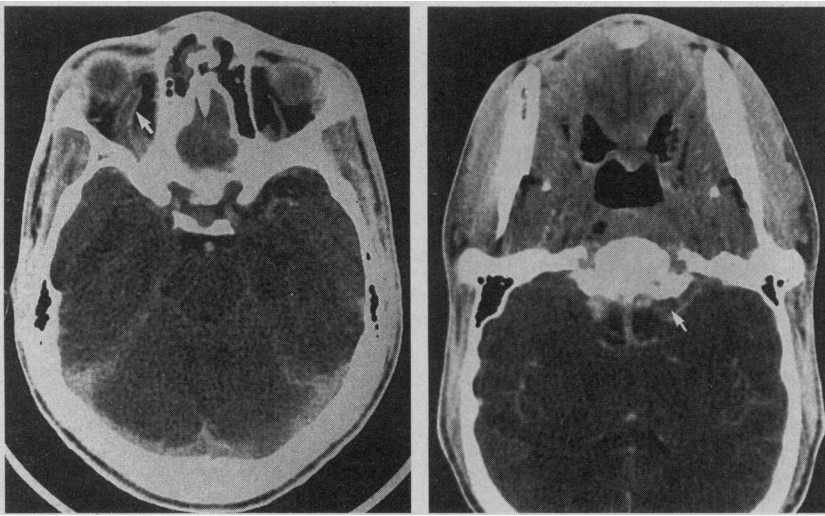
Left, Axial computed tomographic scan of the brain (April 3, 1989) shows right-sided facial and orbital swelling and proptosis and thrombosed right superior ophthalmic vein (arrow). Right, Computed tomographic scan shows enhancement of the right internal carotid artery (arrow) within a thrombosed cavernous sinus (no uptake of contrast) and the left cavernous sinus (enhanced with contrast).
